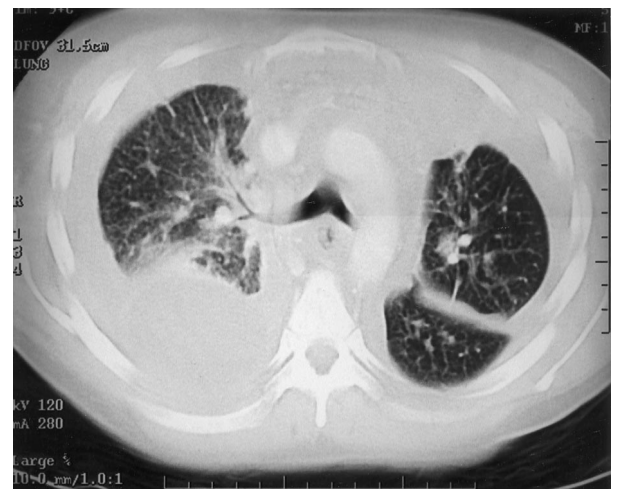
CT scan of the chest at the level of the carina showing bilateral pleural effusion with collapse and consolidation of the right lower lobe and middle lobe and ground-glass opacity in the right upper lobe.
